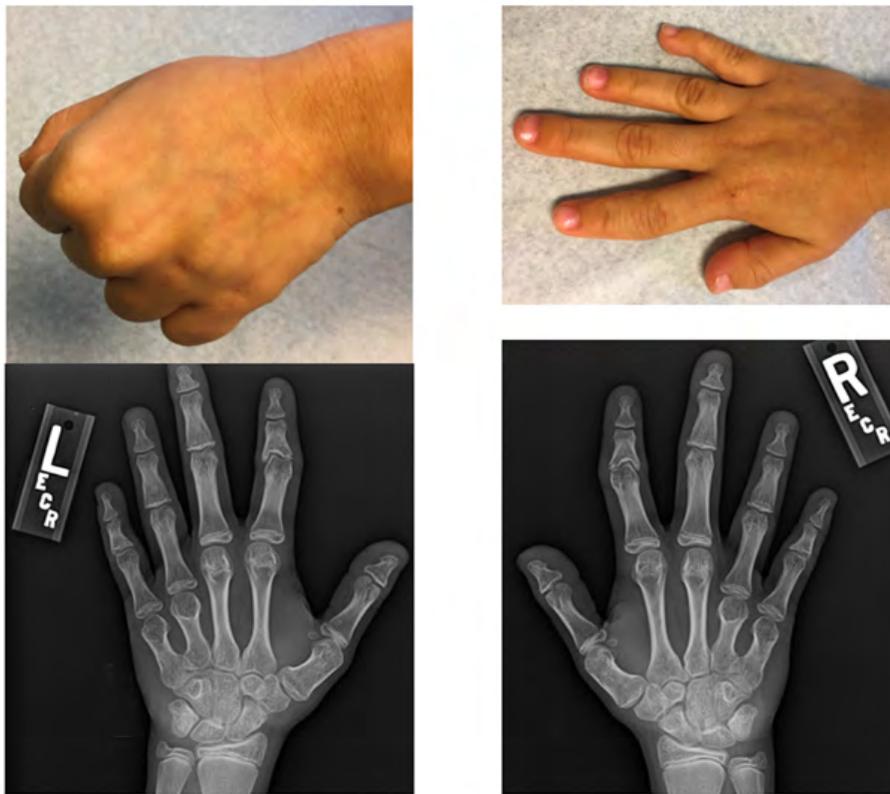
X-rays and pictures of both hands.
